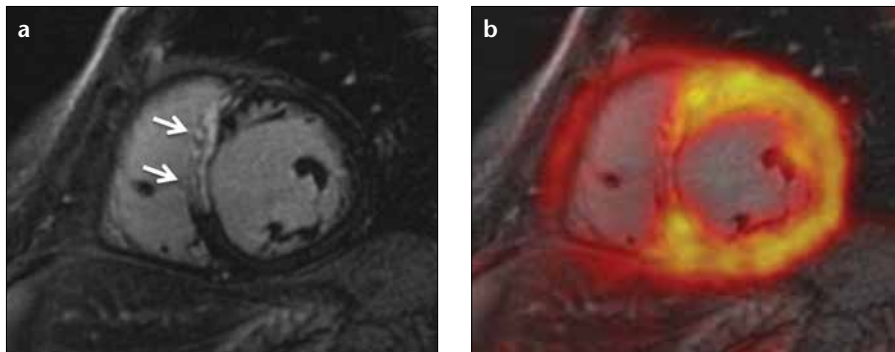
a, b. A patient with acute myocardial infarction due to occlusion of the left anterior descending (LAD) coronary artery. Late gadolinium-enhancement reveals transmural septal infarction (a, arrows) that corresponds to a clearly reduced FDG uptake (b).
